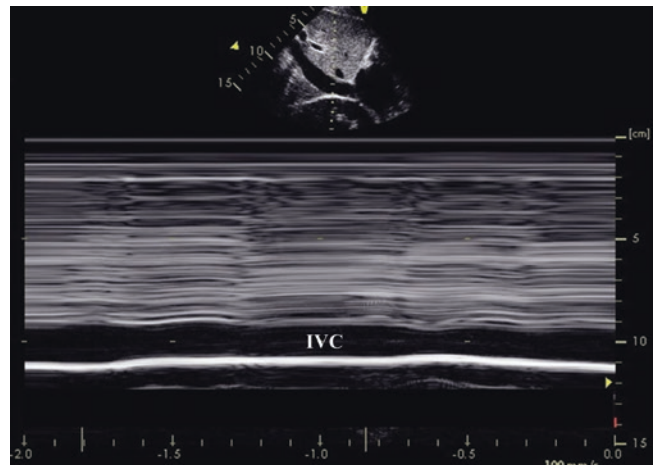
Inferior vena cava assessment using M-mode echocardiography. M mode echocardiogram provides a single-slice view of the structures along the time axis. Due to very high temporal resolution, M mode is helpful in recording and measuring motion over time. It can supplement 2D echocardiogram if it is available on the ultrasound platform. The inferior vena cava (IVC) is seen on the M mode display; it demonstrates little variability in size/collapsibility during the recording
